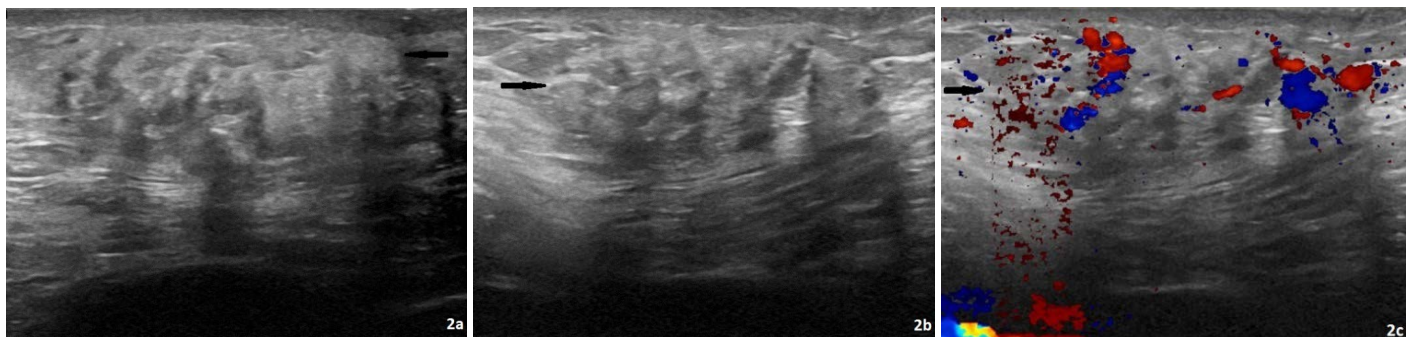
The left breast targeted ultrasound transverse (a) and sagittal (b) images depict a mixed echogenicity, predominantly hyperechoic mass (arrows) with posterior shadowing and increased vascularity (c) in the upper outer breast at palpable site. The left breast targeted ultrasound sagittal color flow (c) image shows increased vascularity (arrow) in the upper outer breast at palpable site.
